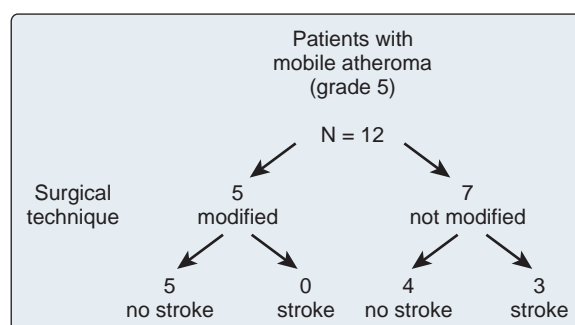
Influence on neurologic outcome of altering operative technique on the basis of the finding of mobile aortic atheromas on transesophageal echocardiography. (Reprinted from Katz ES, Tunick PA, Rusinek H, et al. Protruding aortic atheromas predict stroke in elderly patients undergoing cardiopulmonary bypass: experience with intraoperative transesophageal echocardiography. *J Am Coll Cardiol.* 1992;20:70–77.)
